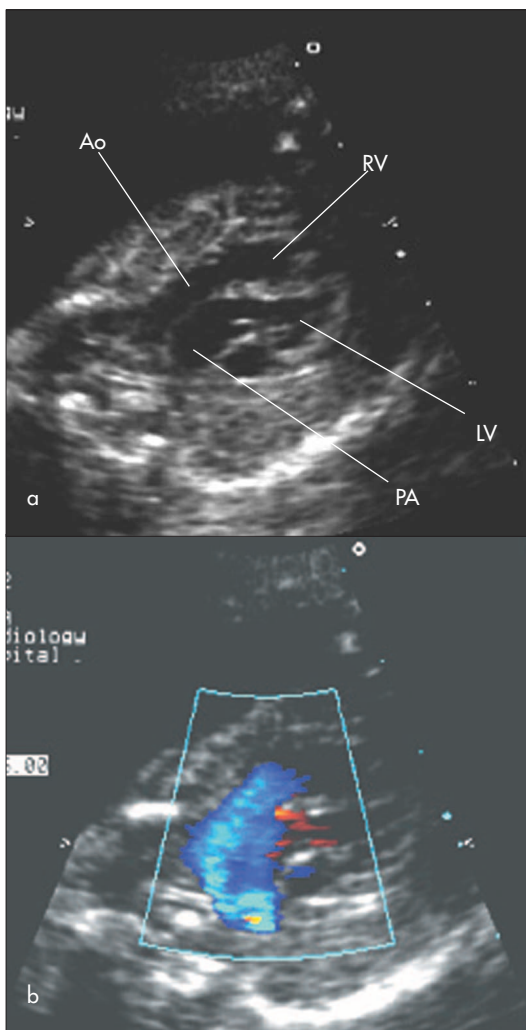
a. Fetal echocardiographic appearances of transposition of the great arteries. The great arteries arise in a more parallel orientation than normal. The four-chamber view is typically entirely normal explaining the relatively poor detection of this lesion during fetal life. Ao = aorta; LV = left ventricle; PA = pulmonary artery; RV = right ventricle. b. Colour flow Doppler demonstrates the flow of blood across the aortic and pulmonary valves. The orientation of the image is identical to Figure 4a.
